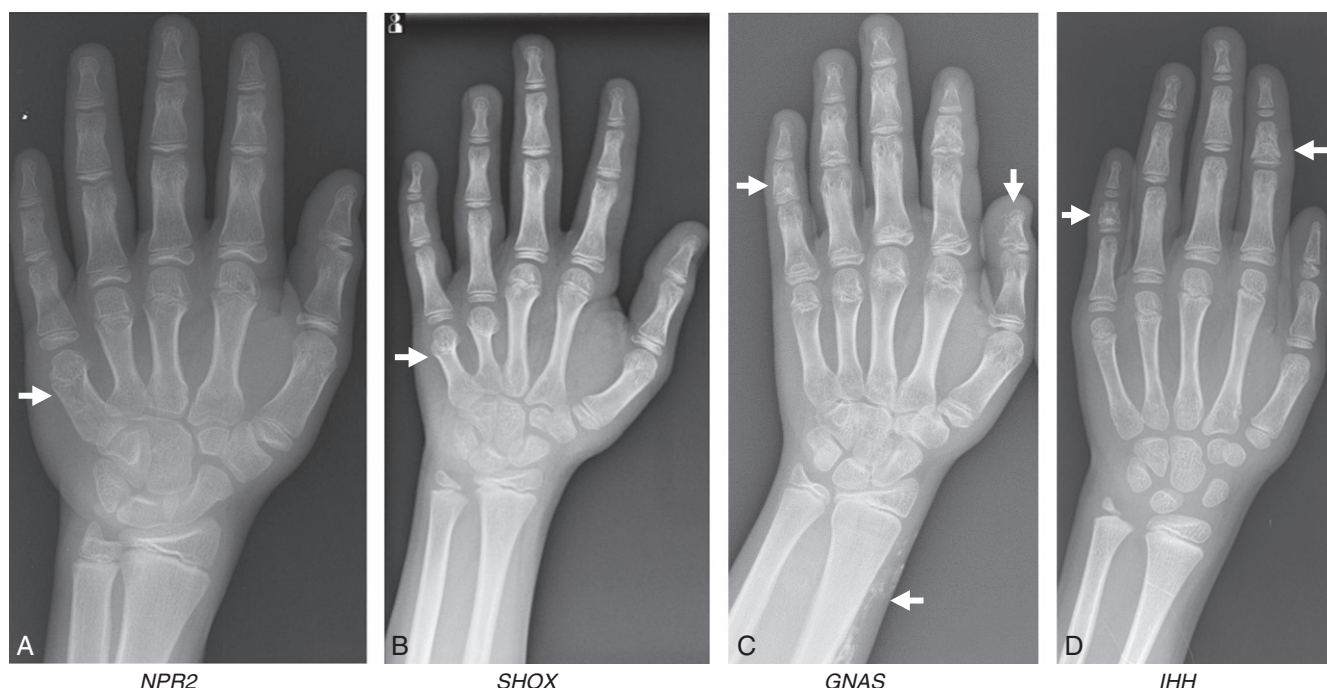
Hand radiographs of children with short stature with nonspecific skeletal abnormalities associated with heterozygous variants in genes involved in growth plate development. A, Short metacarpals observed in some patients with natriuretic peptide receptor 2 (NPR2) variants; B, short fourth and fifth metacarpals in a patient with short stature homeobox (SHOX) haploinsufficiency; C, shortening of middle phalanges and distal phalanx of the thumb with the presence of subcutaneous ossifications in a patient with pseudopseudohypoparathyroidism because of guanine nucleotide binding protein(s) (GNAS) defect inherited from the father; and D, shortening of the middle phalanx of the second and fifth fingers with cone-shaped epiphyses associated with Indian hedgehog (IHH) gene defects.
